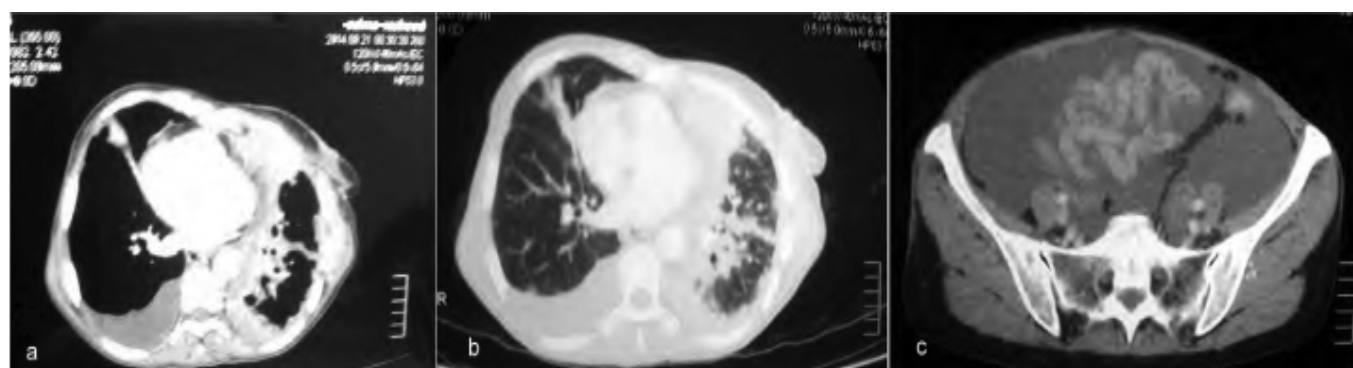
54 years-old female presented with chest pain and dyspnea. Axial contrast-enhanced CT paranchymal (a) and mediastinal sections (b) shows irregular and circumferential left-sided pleural thickening, involvement of interlobar fissure and pericardial involvement with left lung volume contracture. Right sided pleural effusion also noted. (C) axial contrast enhanced CT abdomen shows abdominal involvement inform of ascites proved as malignant ascites by cytological study.
